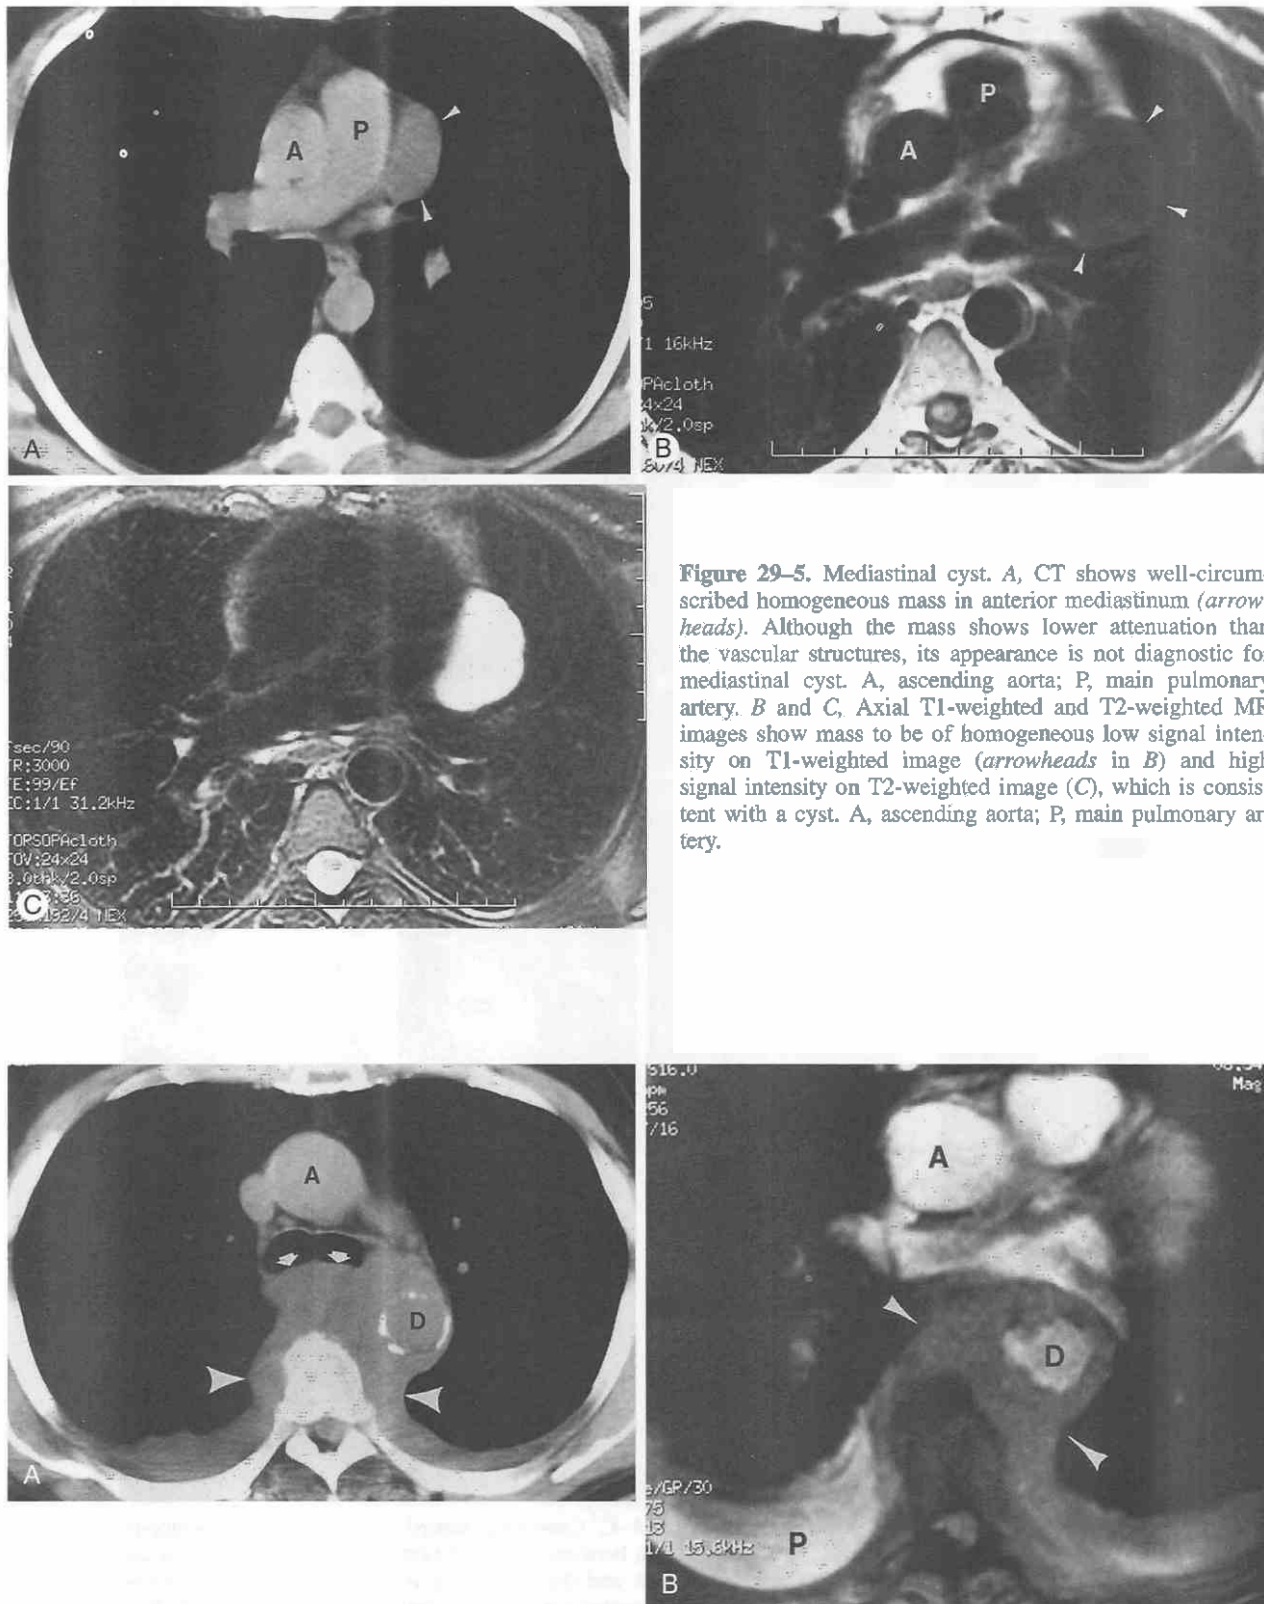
Mediastinal cyst. A, CT shows well-circumscribed homogeneous mass in anterior mediastinum (arrowheads). Although the mass shows lower attenuation than the vascular structures, its appearance is not diagnostic for mediastinal cyst. A, ascending aorta; P, main pulmonary artery. B and C, Axial T1-weighted and T2-weighted MR images show mass to be of homogeneous low signal intensity on T1-weighted image (arrowheads in B) and high signal intensity on T2-weighted image (C), which is consistent with a cyst. A, ascending aorta; P, main pulmonary artery.
